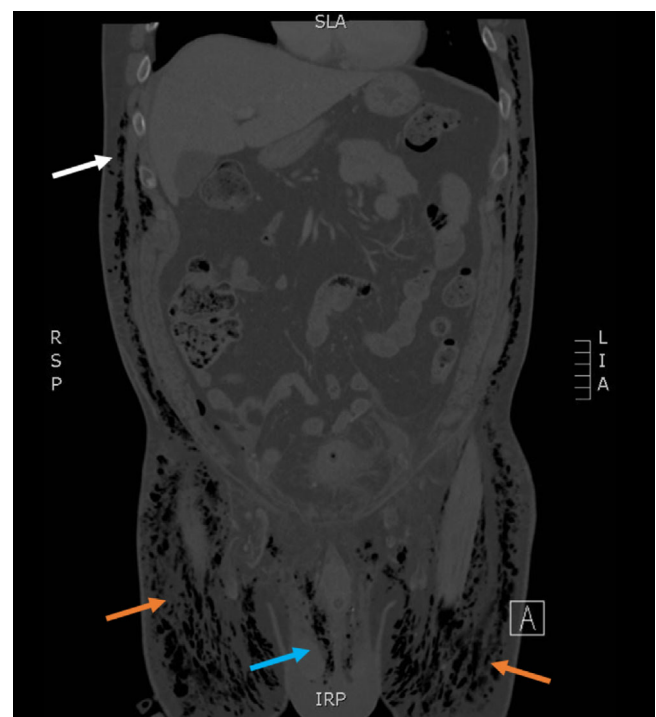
Computed tomography of the abdomen and pelvis (coronal view) revealing subcutaneous emphysema affecting the chest (white arrow), abdominal wall, bilateral lower extremities (orange arrows), and scrotum (blue arrow)
